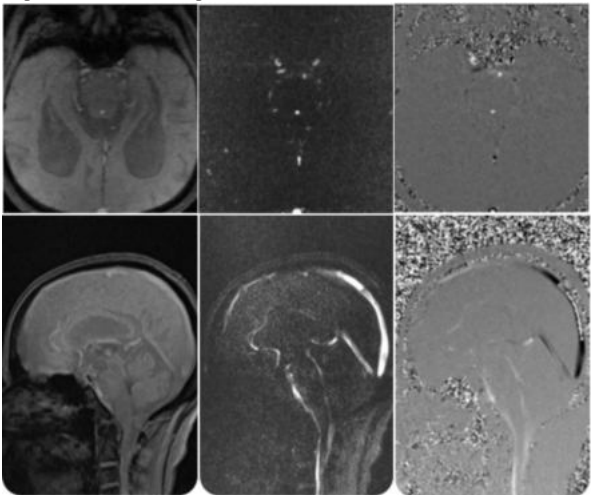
Through-plane & in-plane images of rephased, magnitude & phase series of CSF flowmetry using PC MRI.
